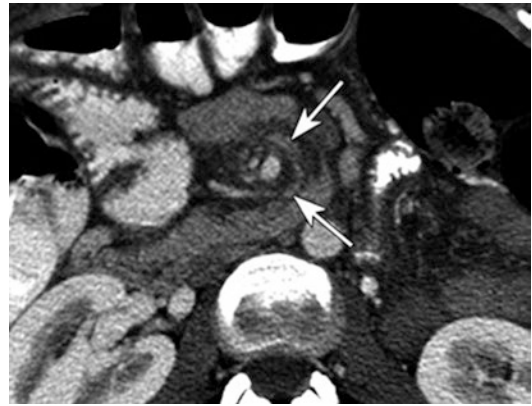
CT scan findings of internal hernia
